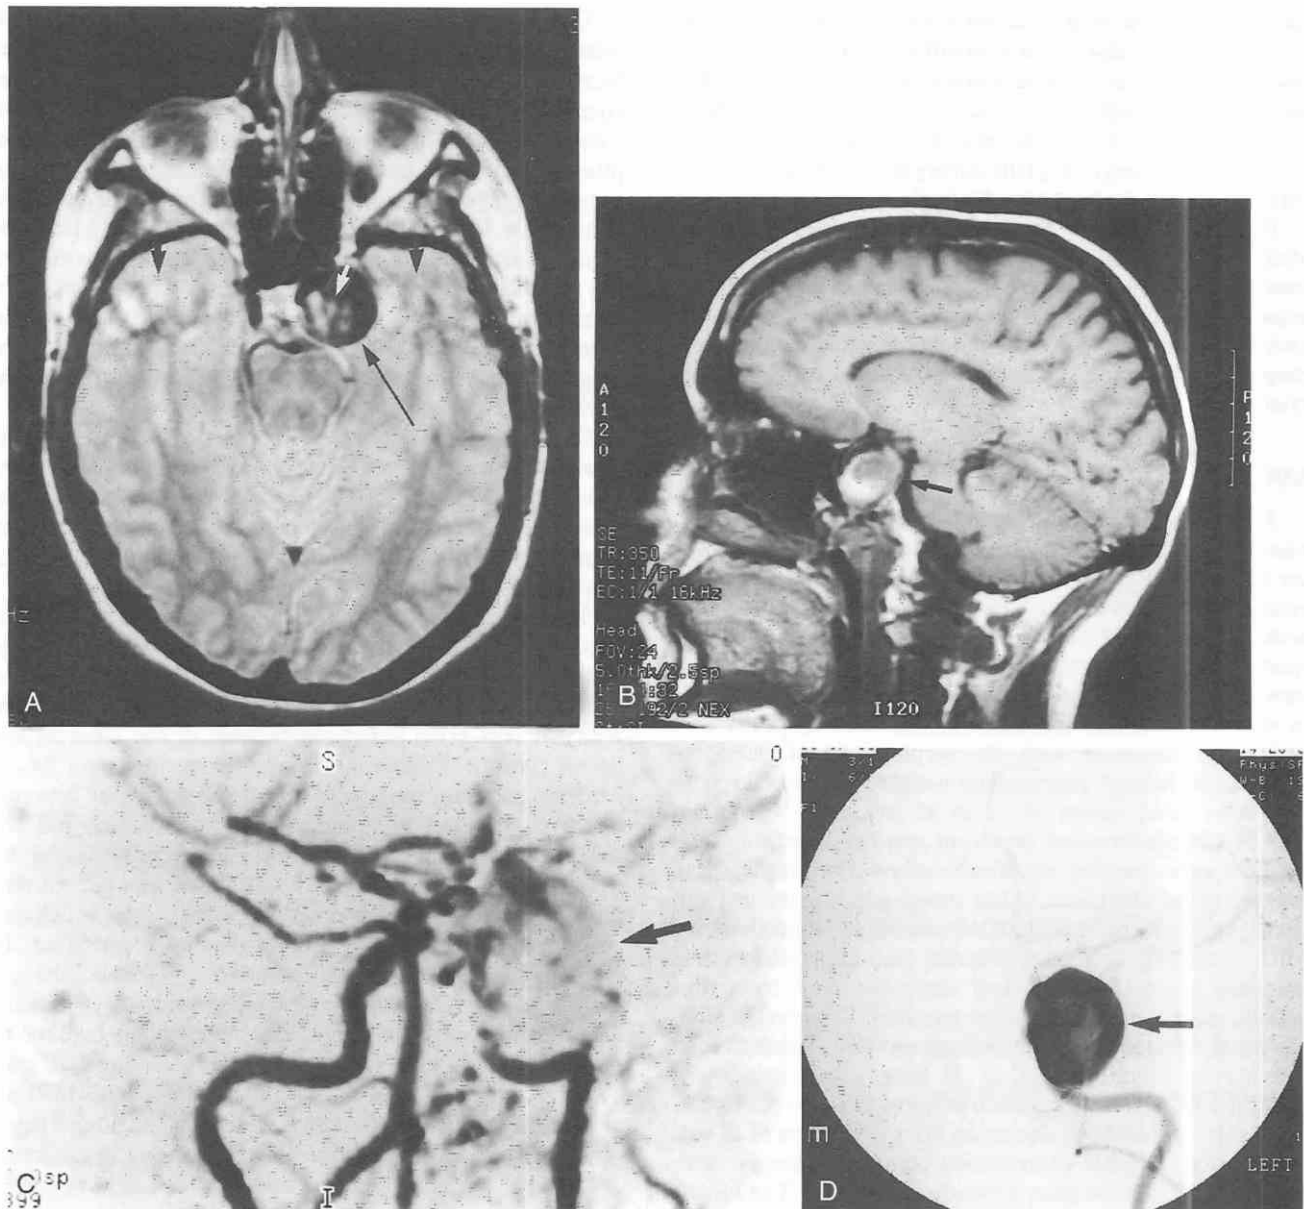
MRI and MRA examination demonstrating flow effects associated with a giant left cavernous carotid aneurysm. *A*, Axial short TE, long TR MR image demonstrating the aneurysm (long arrow) with internal and external phase encoding artifact (short arrows) due to mismatched flow. *B*, Sagittal T1-weighted image falsely gives the appearance of thrombus within the aneurysm (arrow) due to slow flow. *C*, Three-dimensional time-of-flight MRA poorly outlines the aneurysm (arrow) because of internal slow flow. *D*, AP view of left carotid angiogram confirms giant left cavernous carotid aneurysm (arrow). (Case courtesy of Daryl Harp, MD.)
